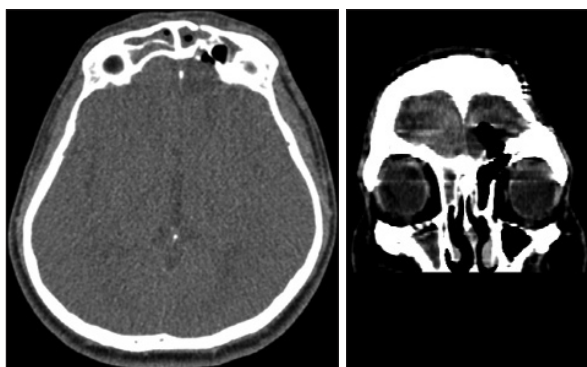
Axial and coronal brain CT scan showing pneumocephalus with frontal sinus opening to the left frontal lobe.
